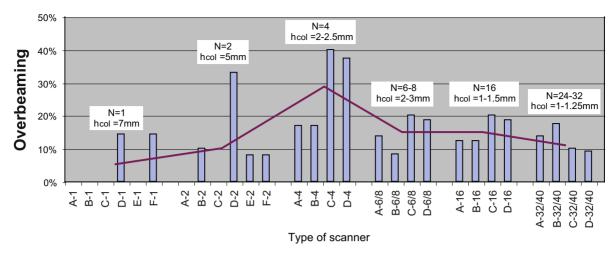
Overbeaming, i.e., the percentage increase in the computed tomography dose index (CTDI), for single-slice (N=1), dual-slice (N=2), quad-slice (N=4), 6 to 8-slice (N=6-8), 16-slice (N=16) and 32 to 40-slice (N=32-40) scanners from different manufacturers (A–F) for the slice collimations h_{col} typically employed. The *red trend line* indicates that overbeaming is most pronounced with quad-slice scanners in practice and is diminished with an increasing beam width N·h_{col}
